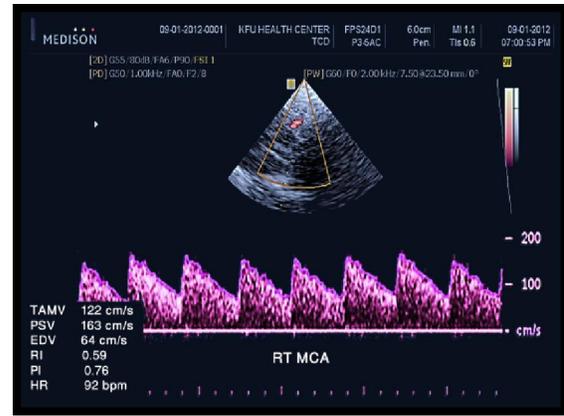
Trans-cranial Color Doppler Ultrasonography with the waveform of the right middle cerebral artery for 9 year-old boy with sickle cell anemia
